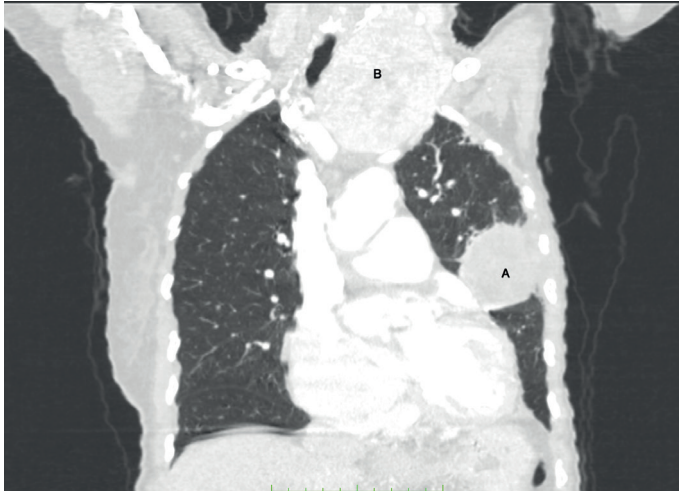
Figure a: Axial cross section of CT Chest showing the pleural base mass
